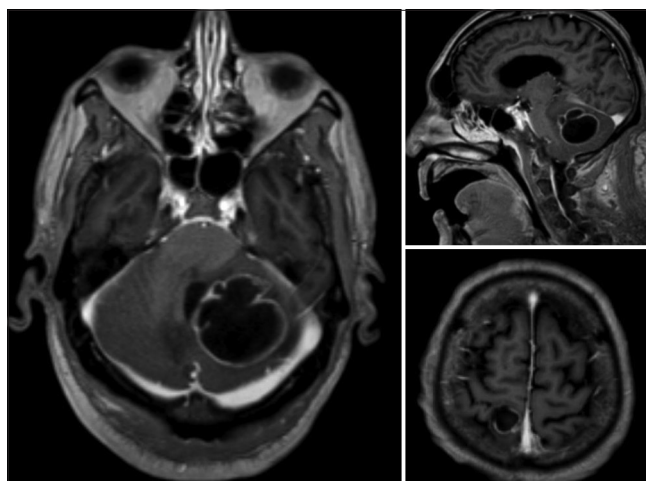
T1-weighted magnetic resonance imaging of the brain. Axial (left) and sagittal (top right) views showing enhancing cerebellar abscess; axial view showing a right parietal abscess (bottom right)
